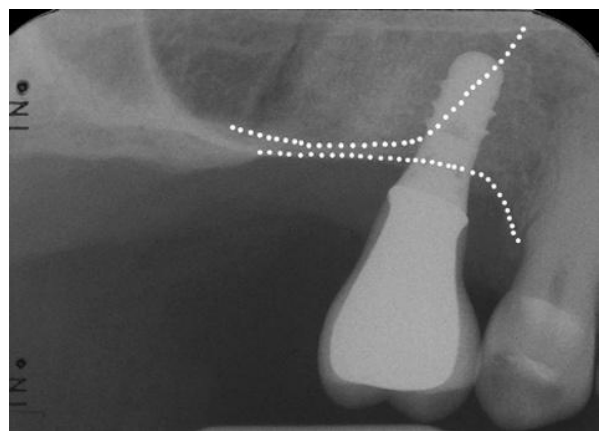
Radiograph of a short (8 mm) implant in the posterior maxilla (dotted lines represent the outlines of the residual bone).
